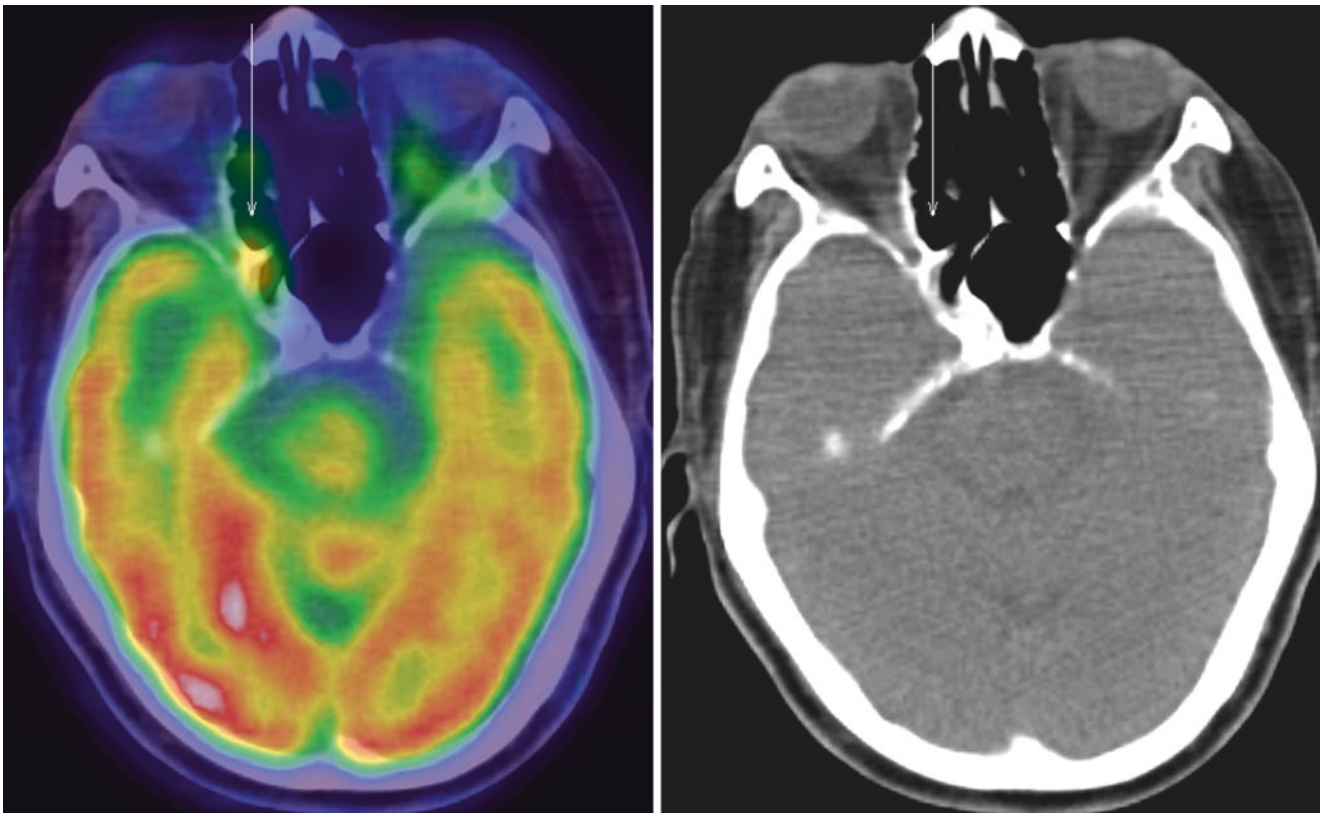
A PET-CT (left) and a CT scan (right), with the arrow pointing to avid uptake of FDG in a tumour at the right orbital apex
